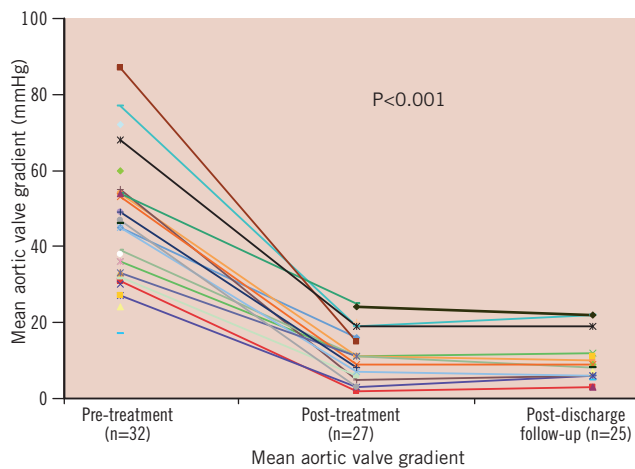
Mean aortic valve gradient (mmHg) during serial echocardiographic evaluation ( $n$ =number of patient echocardiograms with sufficient information for assessment of mean aortic valve gradient).
